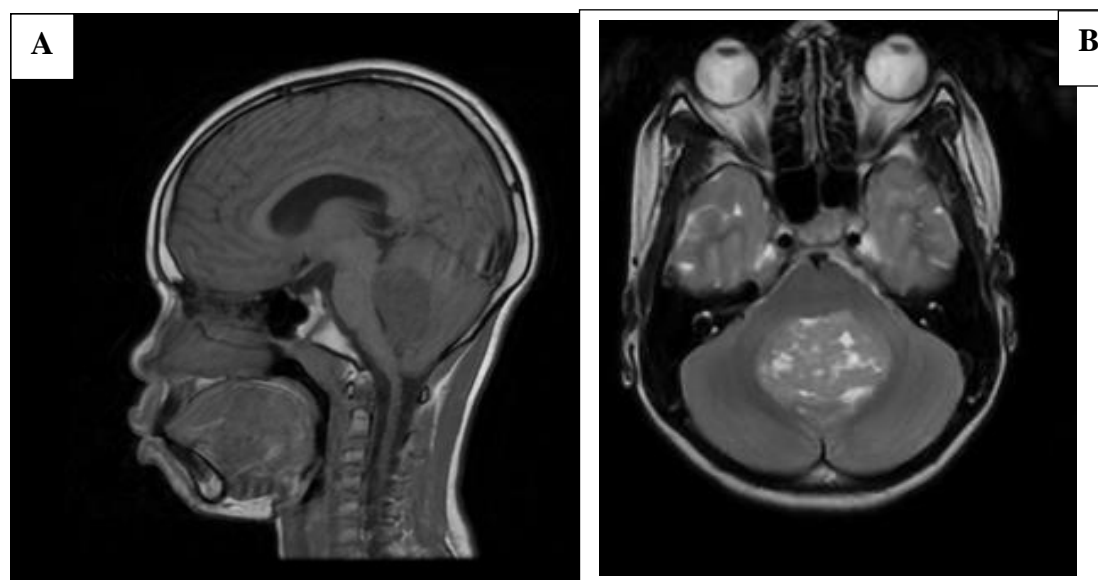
MRI images showing T1 hypointense (A); T2 heterointense (B) lesion in 4th ventricle.
